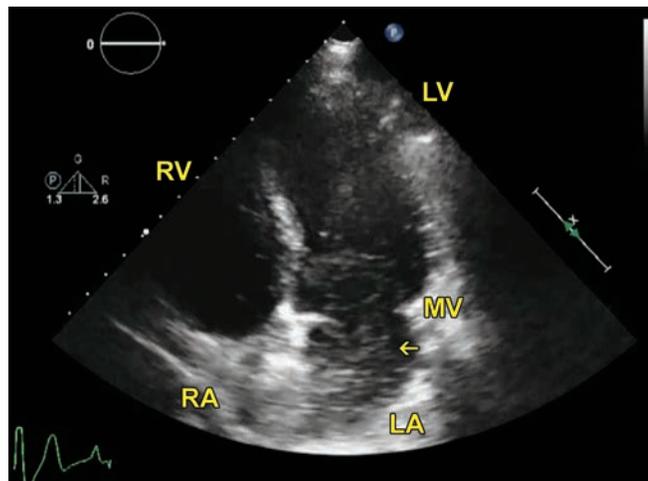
Transthoracic apical 4 chamber view. Arrow points to mass protruding through MV.
